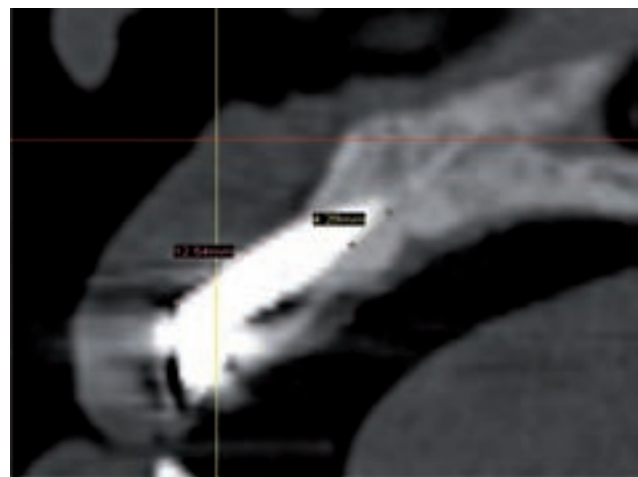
Preoperative CT scan showing 12 mm of the implant devoid of buccal bone.
